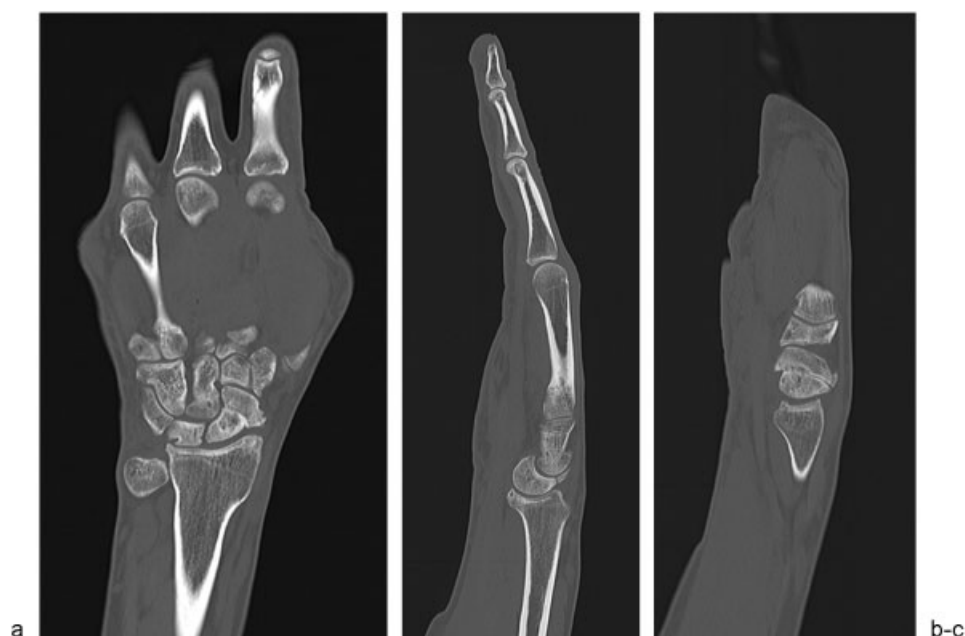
Computed tomography scan images of the collapsed scaphoid. (a) Frontal view shows shortening of the scaphoid and large radial osteophyte. (b-c) Sagittal view demonstrates DISI deformity and shortening of scaphoid with humpback deformity.
